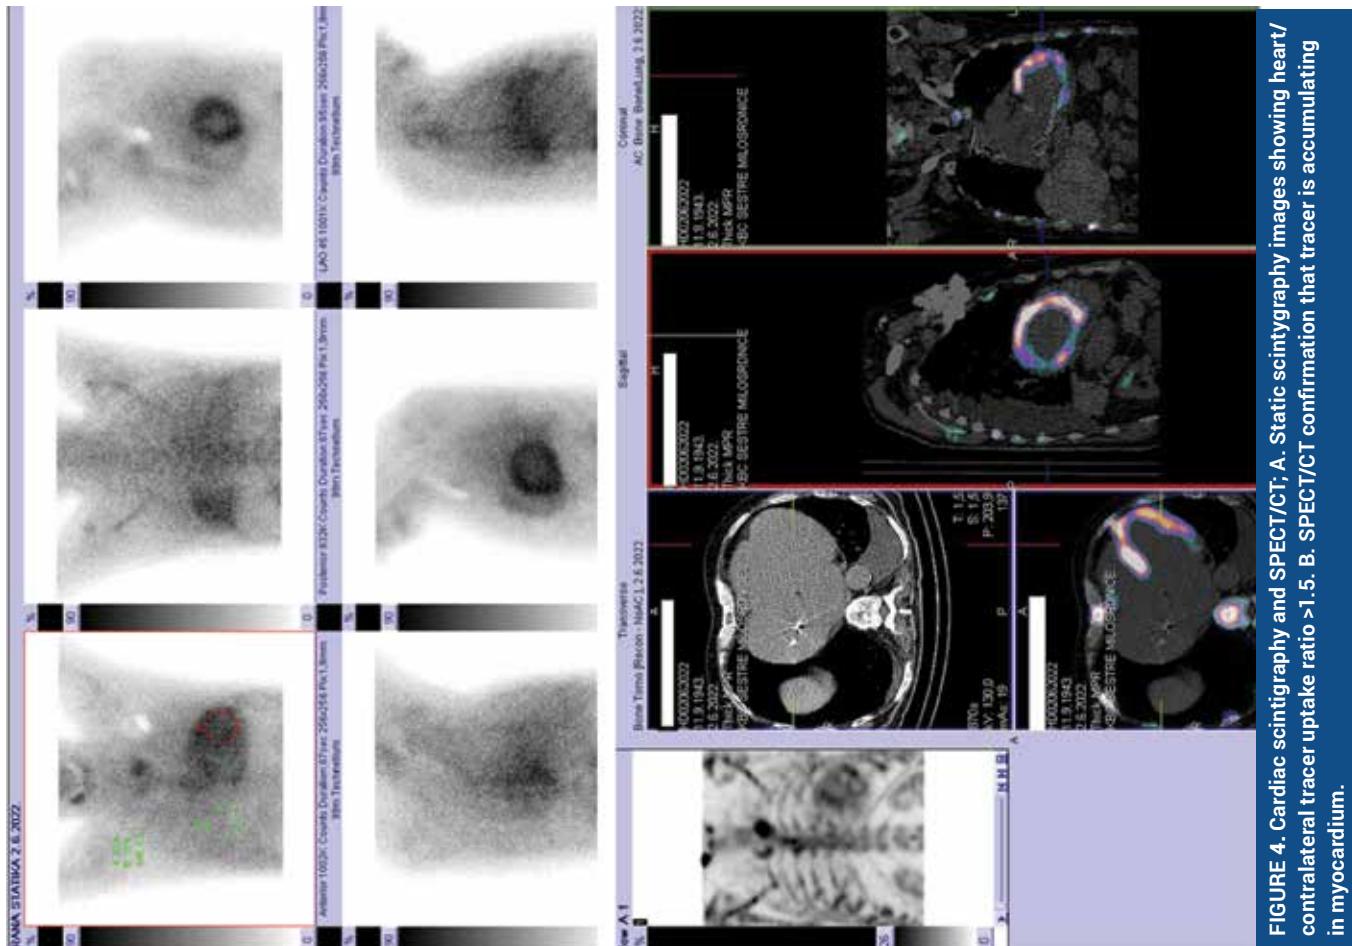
Cardiac scintigraphy and SPECT/CT; A. Static scintigraphy images showing heart/contralateral tracer uptake ratio  $>1.5$ . B. SPECT/CT confirmation that tracer is accumulating in myocardium.
